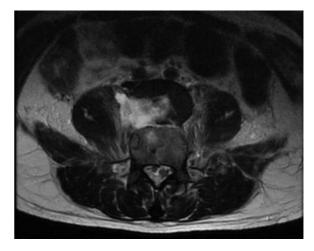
Magnetic resonance imaging, axial view, showing the L4 vertebral body posterior to L5.
